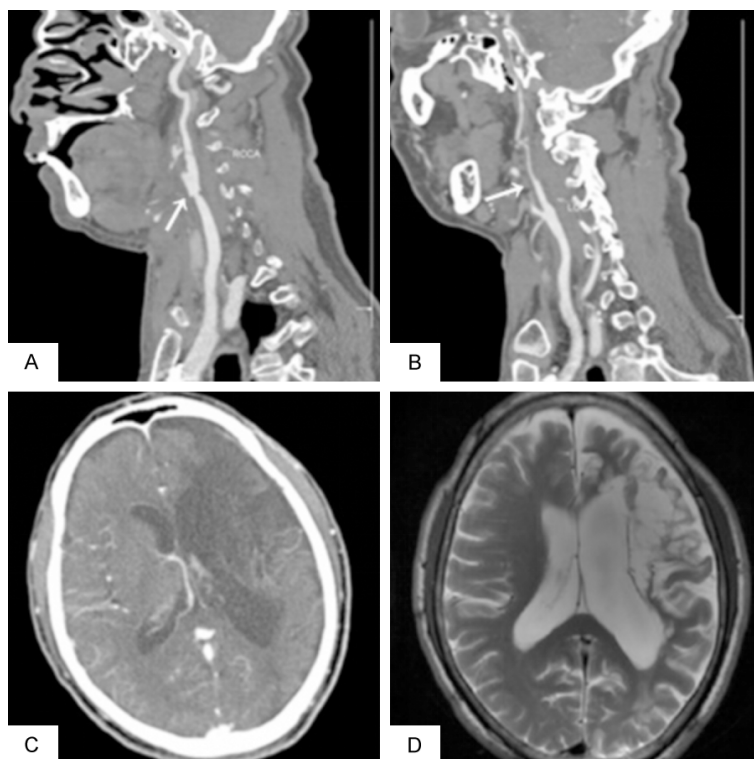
A. Carotid CTA showed that the lumen was patent after endarterectomy of the right internal carotid artery; B. Carotid CTA showed spontaneous recanalization of the left internal carotid artery, the stenosis rate was about 90%; C. Enhanced cranial CT scan showed a large infarction in the left frontal lobe, which was larger than before the operation; D. Before CEA, the head MRI-T2WI of the same patient showed an old infarction at the same level.
